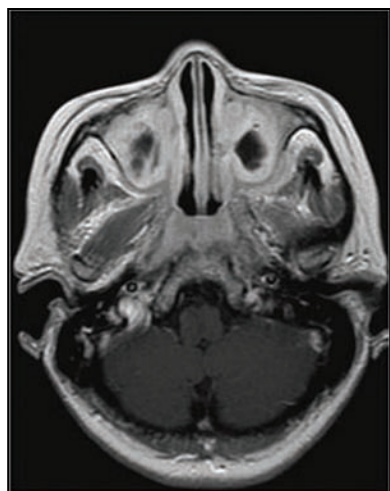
Axial T1 weighted sequence magnetic resonance image of the brain with gadolinium contrast demonstrating extensive pansinusitis.
